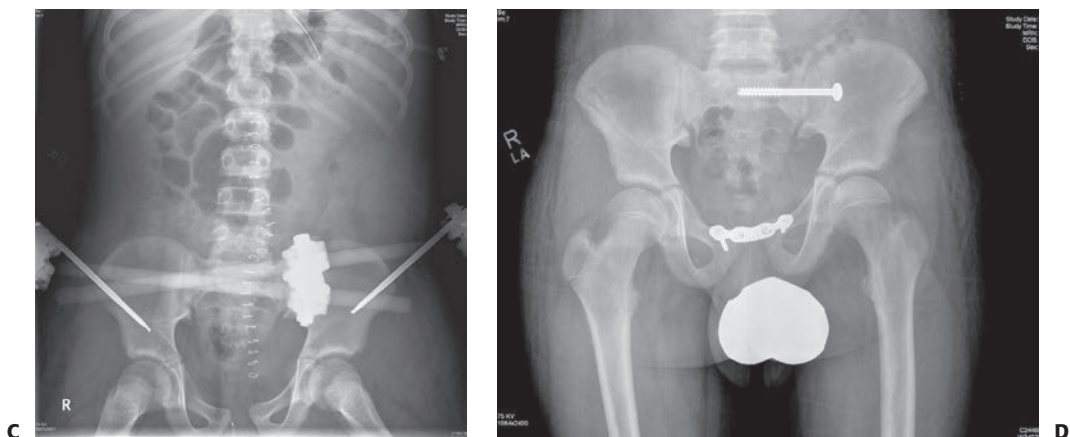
(continued) C: Pelvic radiograph after an anterior external fixation was placed urgently to stabilize the pelvis. This along with resuscitation stabilized the hemodynamic status. D: Once the patient had stabilized, the external fixation was converted to anterior internal fixation with a plate on the symphysis pubis and the posterior instability was treated with a sacroiliac screw.
